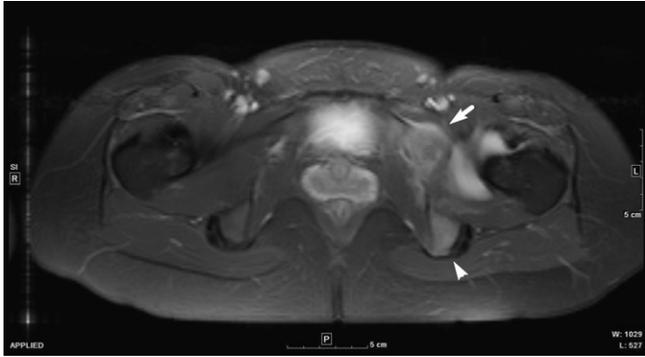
An axial fat-suppressed contrast-enhanced T1-weighted MR image of the pelvis showed enhancing soft tissue at the left acetabulum (arrow) and the left ischium (arrowhead), along with bony cortex destruction.
